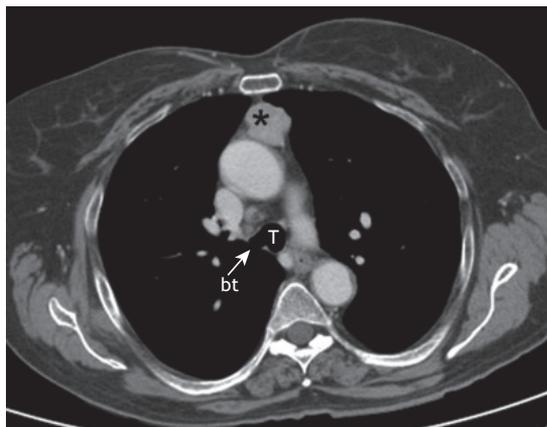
Axial CT scan of the chest, showing a solid mass in the anterior mediastinum (asterisk), consistent with a thymoma. Note the tracheal bronchus (bt) branching off from the trachea (T).
